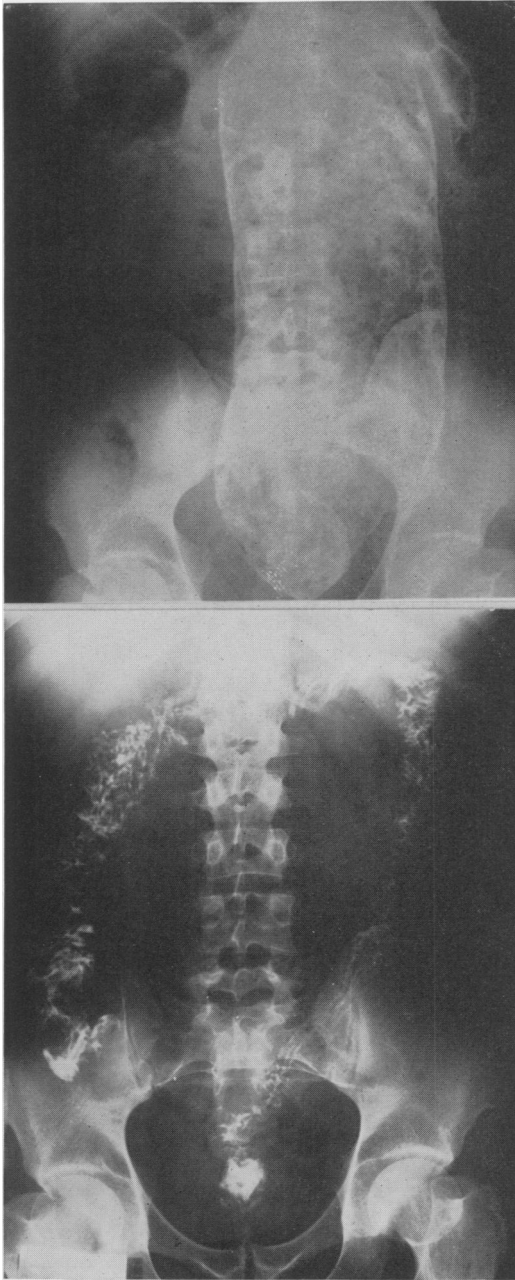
Roentgenogram of a young adult with severe Hirschsprung's disease. B. Follow up roentgenogram of same patient. Both roentgenograms were postevacuation. Note the completeness of emptying in the postoperative film. From Swenson, O.: *J. A. M. A.*, 154: 651, 1954, and Swenson, O., R. H. Segnitz and R. H. Shedd: *Am. J. Surg.*, 81: 341, 1951.
